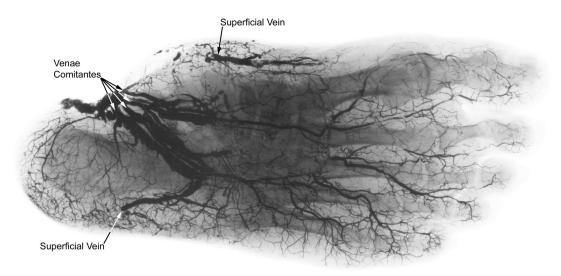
Radiograph of the arterial and venous anatomy of the foot following perfusion an isolated foot. Veins can been seen to the level of the midfoot where valves have halted distal progression of the lead oxide mixture.
